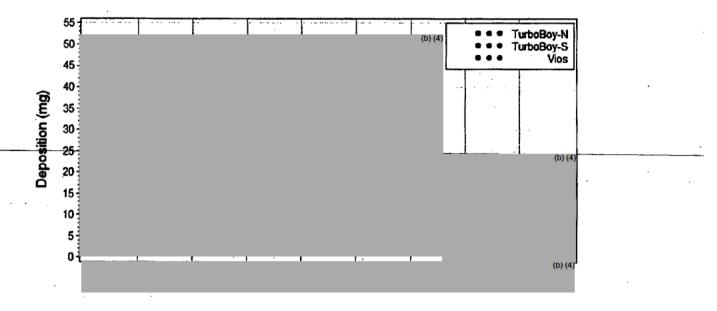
Individual-Stage NGI Deposition for the TBM Configuration and CT Configurations
